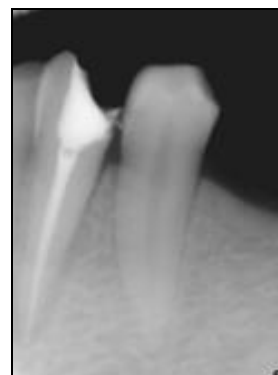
Pre-operative radiograph showing overextended root canal filling
